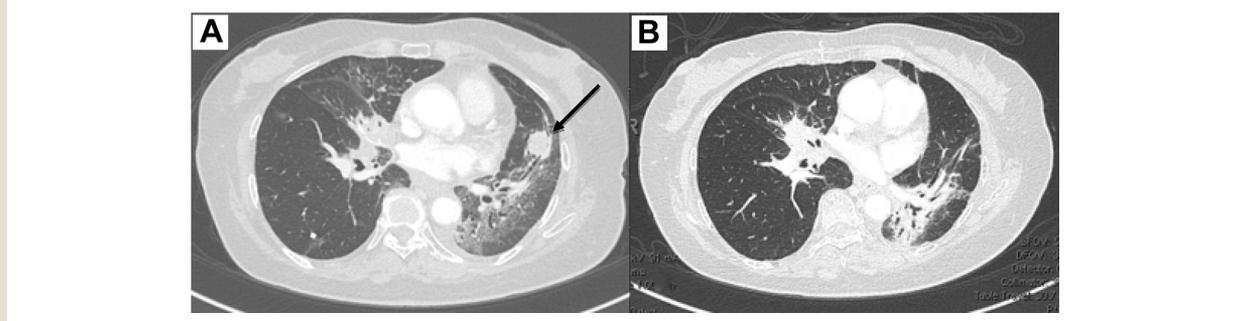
Computed Tomography Images Demonstrating (A) Baseline and (B) Maximal Response After 4 Cycles of Atezolizumab
